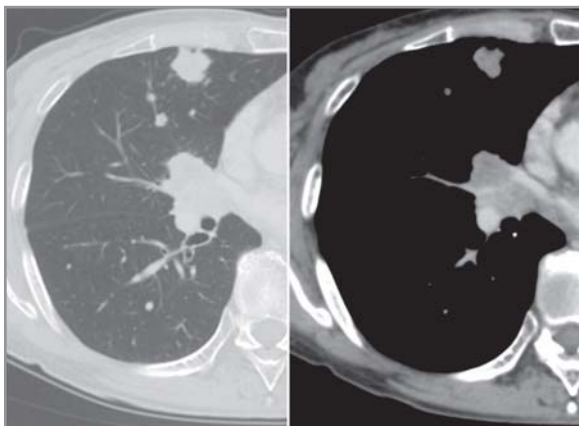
Chest radiography and CT scan revealed a mass of 25 mm in diameter in right middle lobe with ipsilateral mediastinal lymph node swelling.
